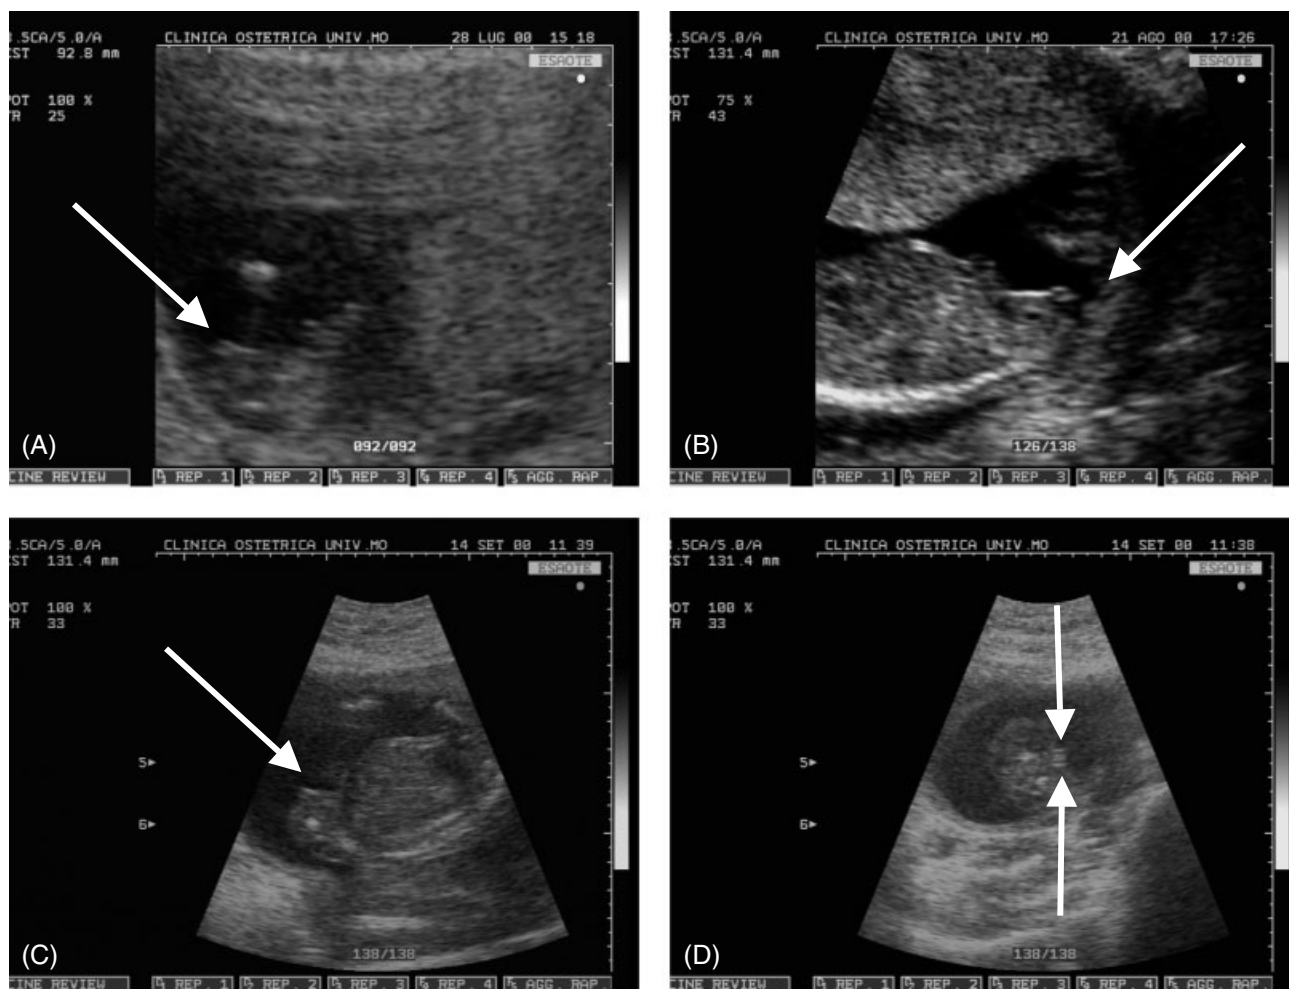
Sonography for fetal-gender assignment. (A, B, C) Sagittal sections of external genitalia at 21-, 30- and 41-mm BPD, respectively. The arrows point to the bulge/clitoris. (D) Coronal section of external genitalia at 41-mm BPD. The arrows point to the labia majora and minora
